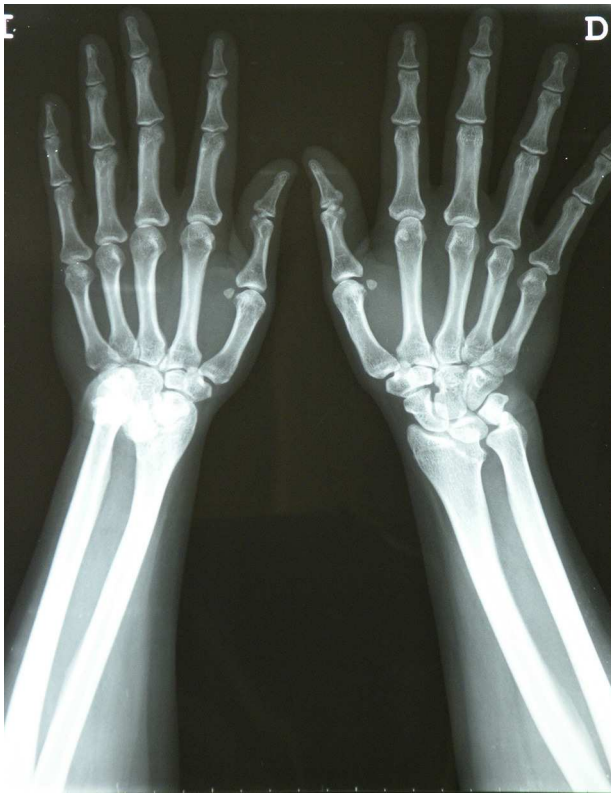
Posteroanterior X-ray of both wrists.
